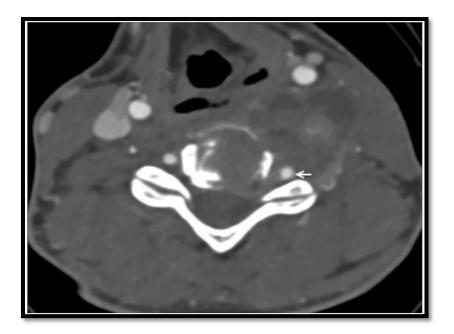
Axial computed tomography angiogram image showing tumor displaced left carotid vessels anteriorly and encasing left vertebral artery (arrow).
